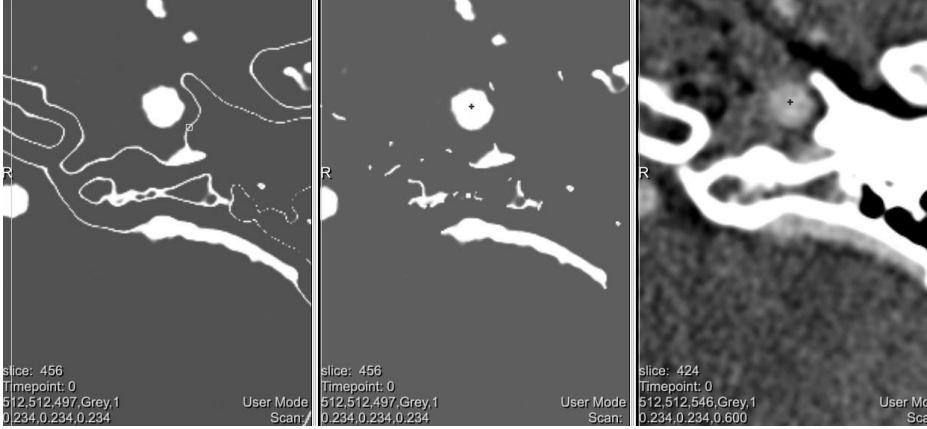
Morphological opening applied on the intensity – range image to remove bony structures. Left: intensity-range image $P(I(x))$ before opening; Center: $P(I(x))$ after opening is applied; extracted centerline position is indicated with a dot; Right: original CTA image.
